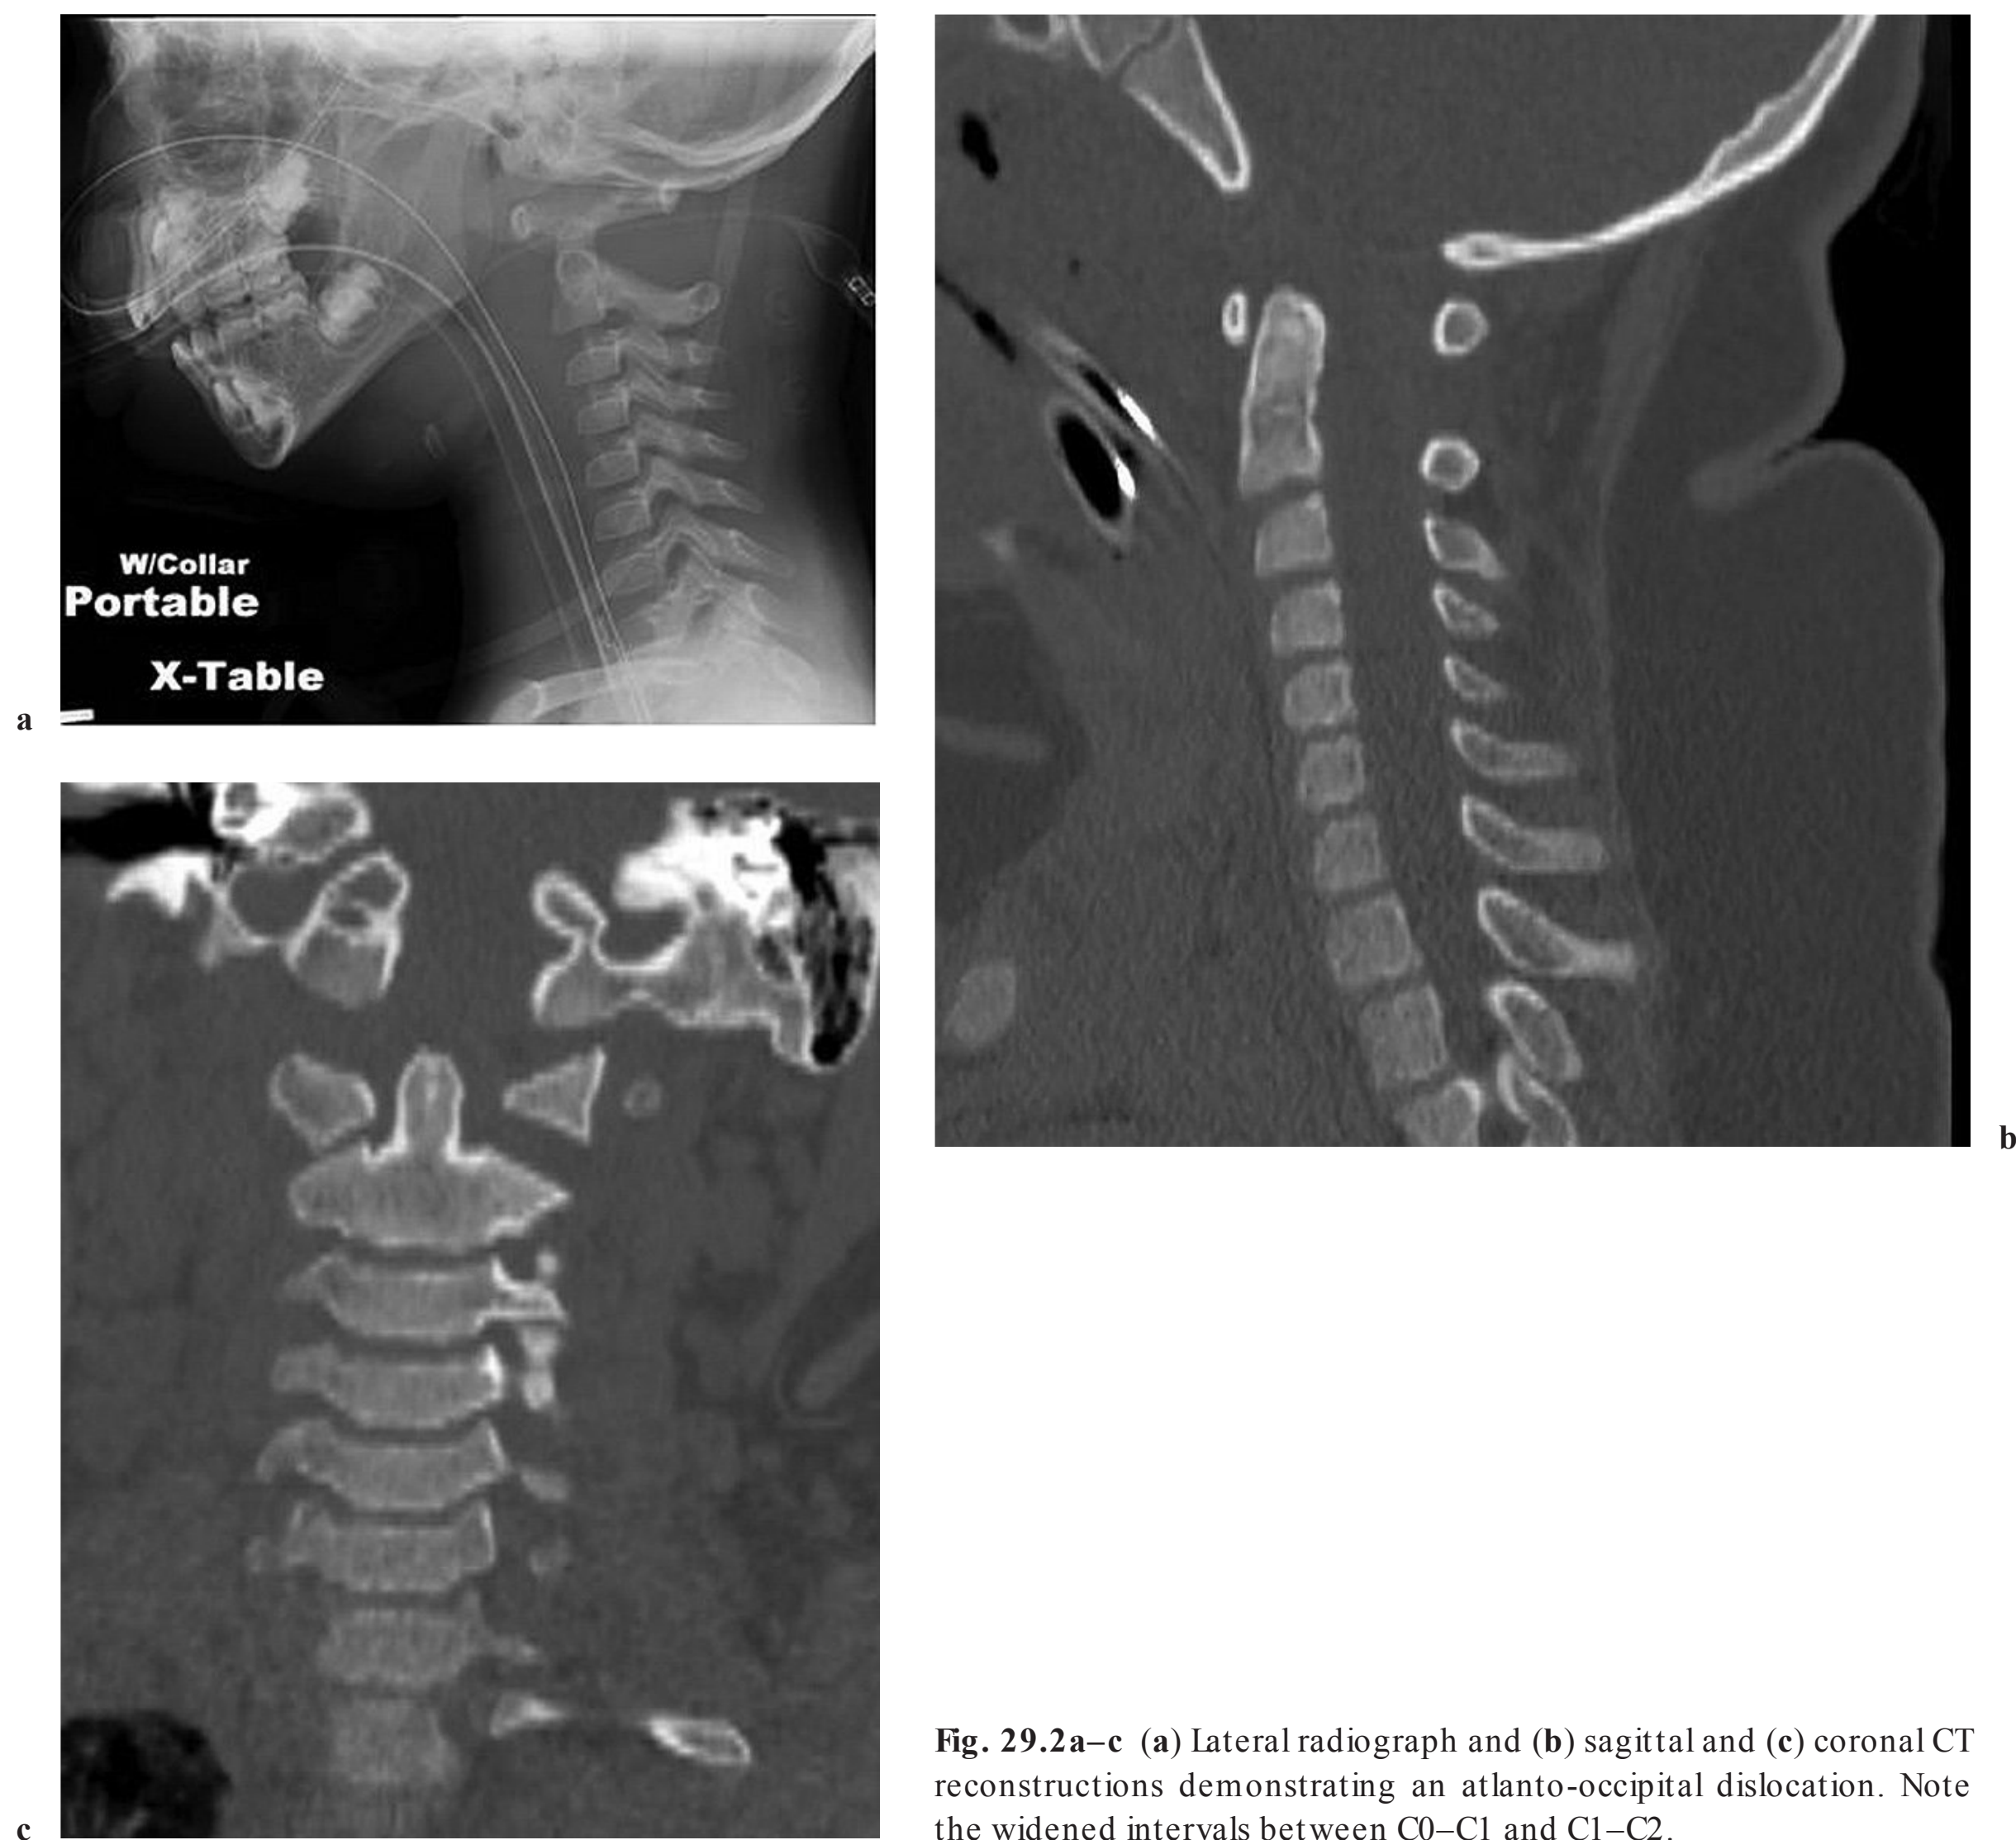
c (a) Lateral radiograph and (b) sagittal and (c) coronal CT reconstructions demonstrating an atlanto-occipital dislocation. Note the widened intervals between C0–C1 and C1–C2.
